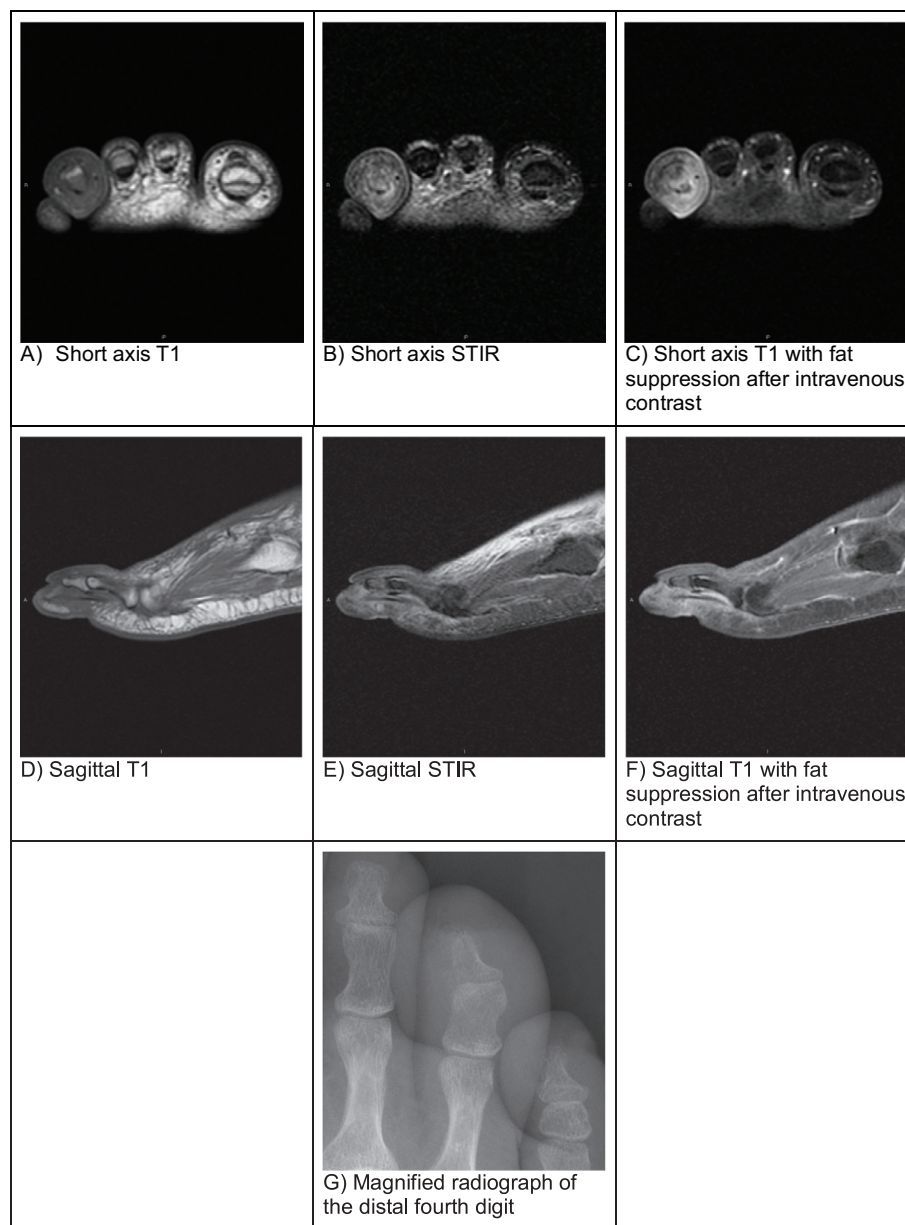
A 38-year-old male without significant medical history presenting with uncomplicated cellulitis and osteomyelitis of the fourth digit. There is hypointense marrow signal on T1-weighted images of the fourth distal and middle phalanges (A,D). There is corresponding short-T1 inversion recovery (STIR) imaging hyperintensity (B,E) and postcontrast enhancement (C,F). Soft tissue swelling and edema surround the fourth digit, tracking along the forefoot dorsum. Radiography better demonstrates cortical erosion of the distal phalanx (G). Imaging and clinical examination were negative for abscess or ulceration.
